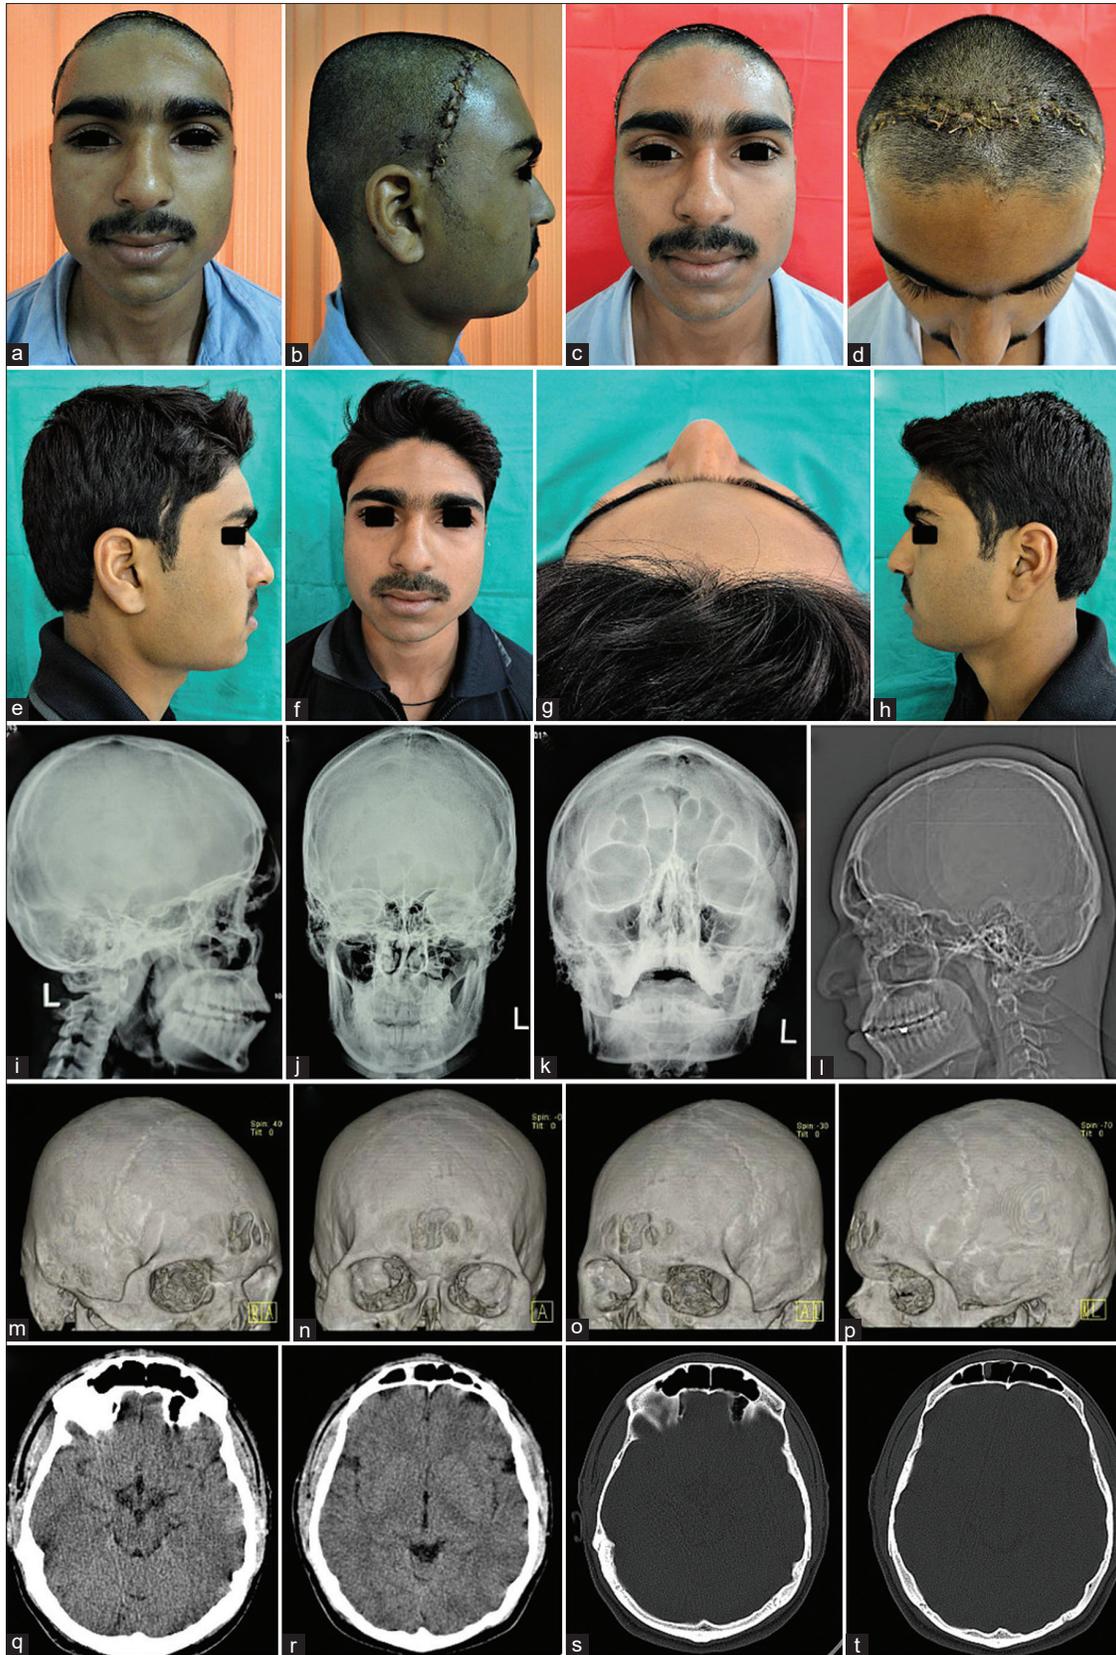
(Case 2) (a-d) Appearance on the 4th postoperative day, showing good restoration of the cranial contour and facial esthetics. (e-h) One-year postoperative appearance showing no evidence of recurrence or progression of the lesion. The bicoronal incision scar was camouflaged well within the hairline. (i-l) Lateral, posteroanterior, and occipitomental view radiographs and (m-t) noncontrast computed tomography of craniomaxillofacial region taken postoperatively, showing successful removal of the protuberant bone pathology from the glabella region and restoration of its normal contour
